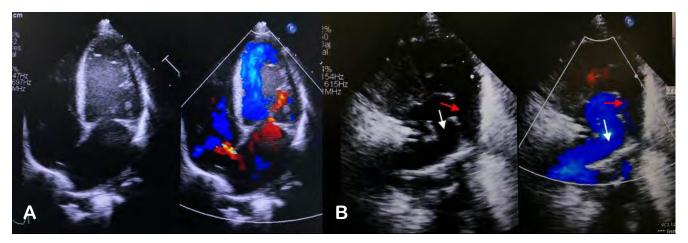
Two-dimensional transthoracic echocardiogram. Two-dimensional transthoracic echocardiogram: a) 4-chamber axis with patent foramen ovale with shunt from left to right, intact interventricular septum, and mild mitral regurgitation. B) axis of the great vessels showing the aortopulmonary window (red arrow) and the origin of the right pulmonary branch of the ascending aorta (white arrow).
